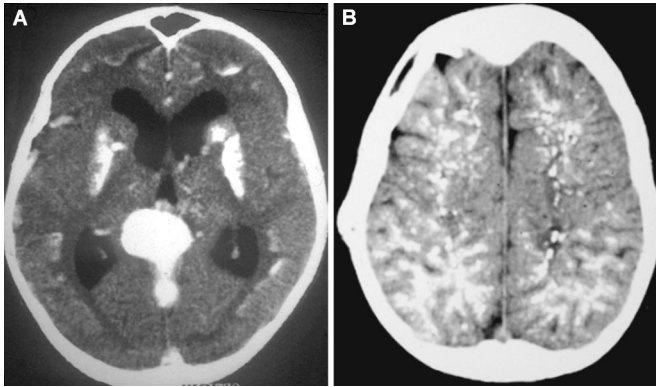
A and B, axial computed tomographic scans showing diffuse intracranial calcifications in two patients with VGAM who were referred late for treatment. These calcifications are the results of a longstanding hydrovenous disorder.
